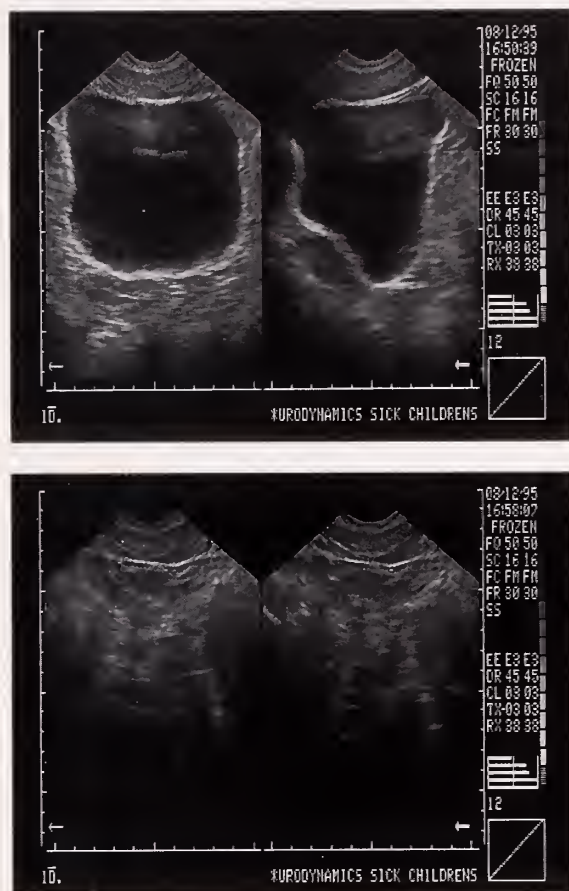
Pre- and post-void bladder sonography is a painless way to document bladder emptying (post-void residual). Top, full bladder. Bottom, empty bladder = zero post-void residual.
